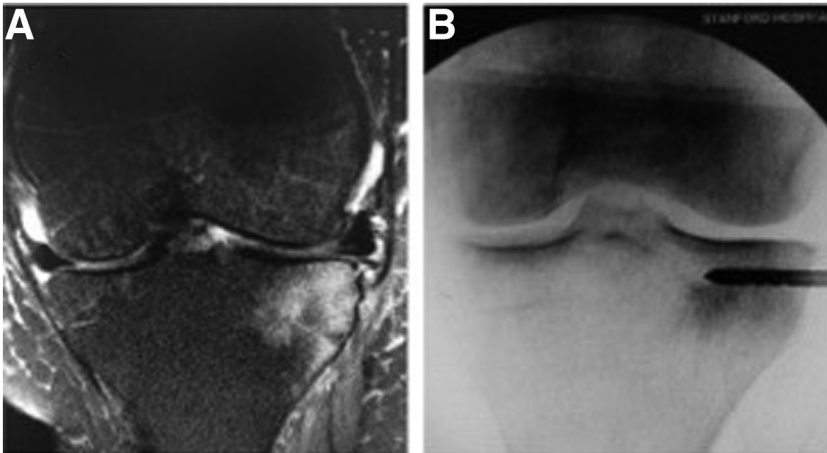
(A) Coronal magnetic resonance imaging shows a bone marrow lesion localized to the lateral left tibia. (B) Core decompression of the bone marrow lesion using the decompression route is performed through the nearest lateral cortex on fluoroscopy with the patient lying supine.
